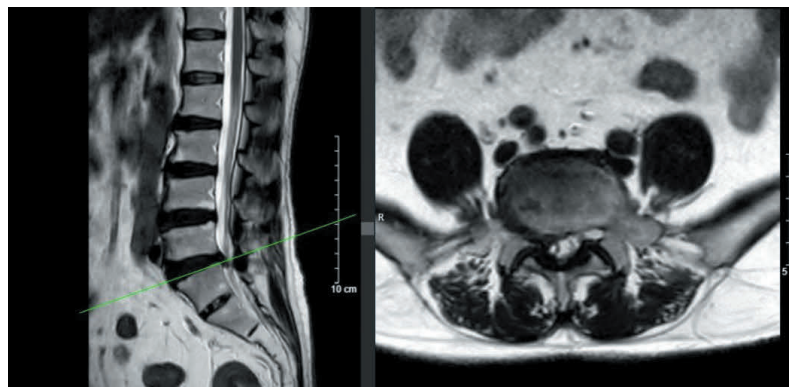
MRI image of Lumbar spine from September 10, 2024: no change in L4/5 disc herniation.
